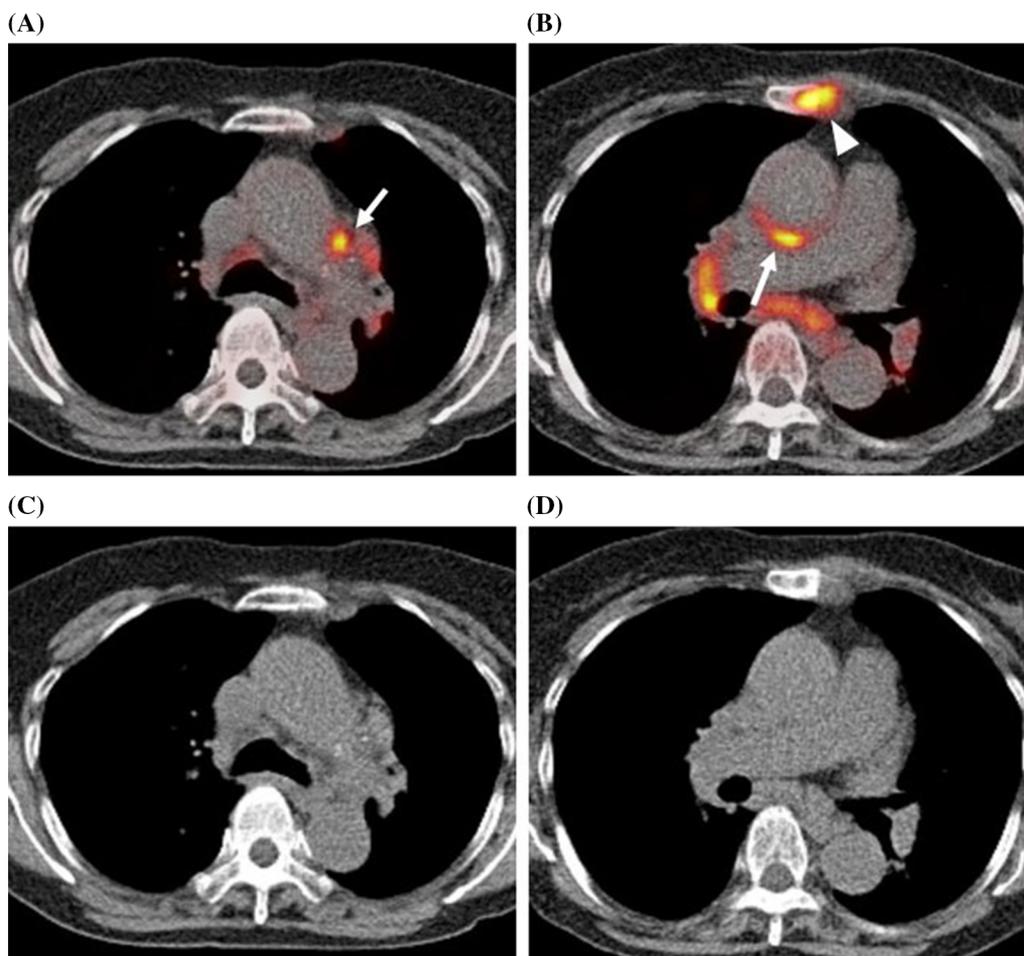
^{18}F -FDG PET/CT fusion images (A, B) showing focal increased uptake within aortic arch (arrow) and ascending aorta (arrow) and avid uptake in sternum (arrowhead) and mediastinal and hilar lymph nodes (B). Anatomical abnormalities absent on CT (C, D).
